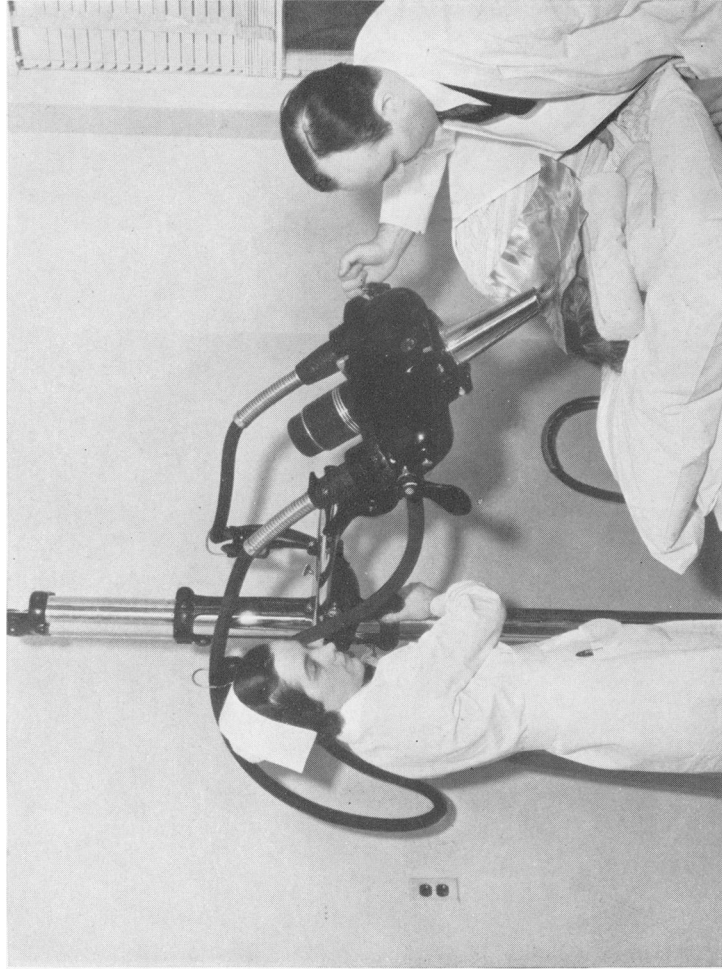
Doctor and nurse prepare patient for X-ray therapy. Radiation will be applied to malignant growth on the ear. A protective lead shield is placed around the cancerous area.
